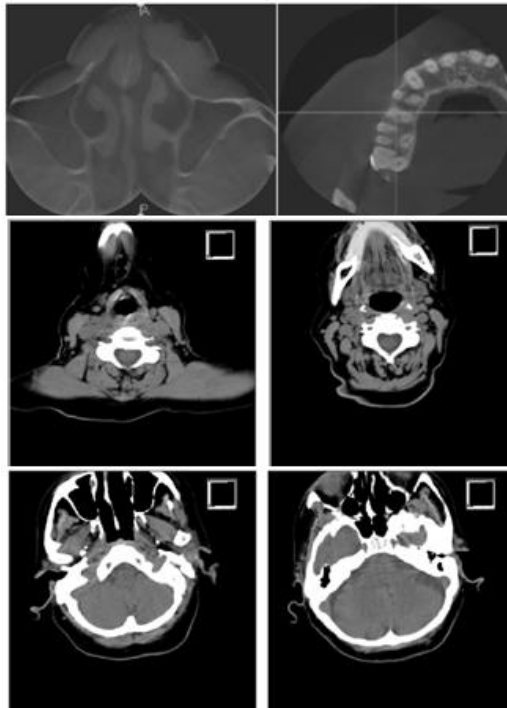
The CT images of analyzed patients.
